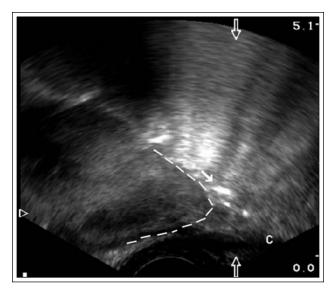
Intra-operative transrectal ultrasound image of prostate apex during LRP (picture courtesy of Dr. Osamu Ukimura).
